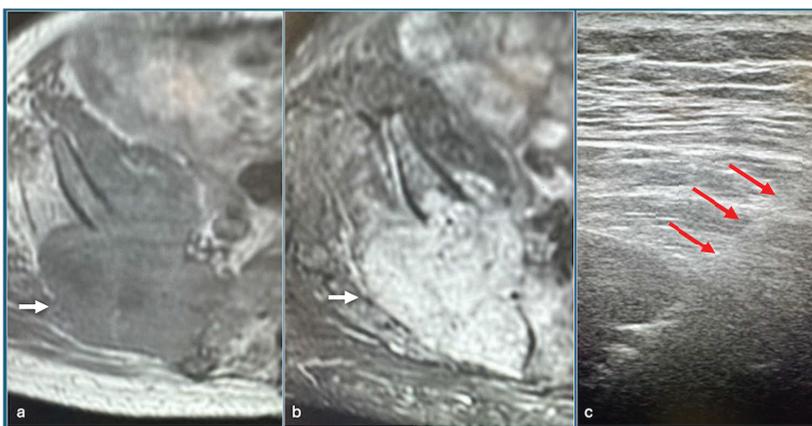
Axial T1 (a), STIR (b) shows tumour (arrow) involving right posterior ilium and Ultrasound-guided biopsy (c) showing needle (red arrows).
